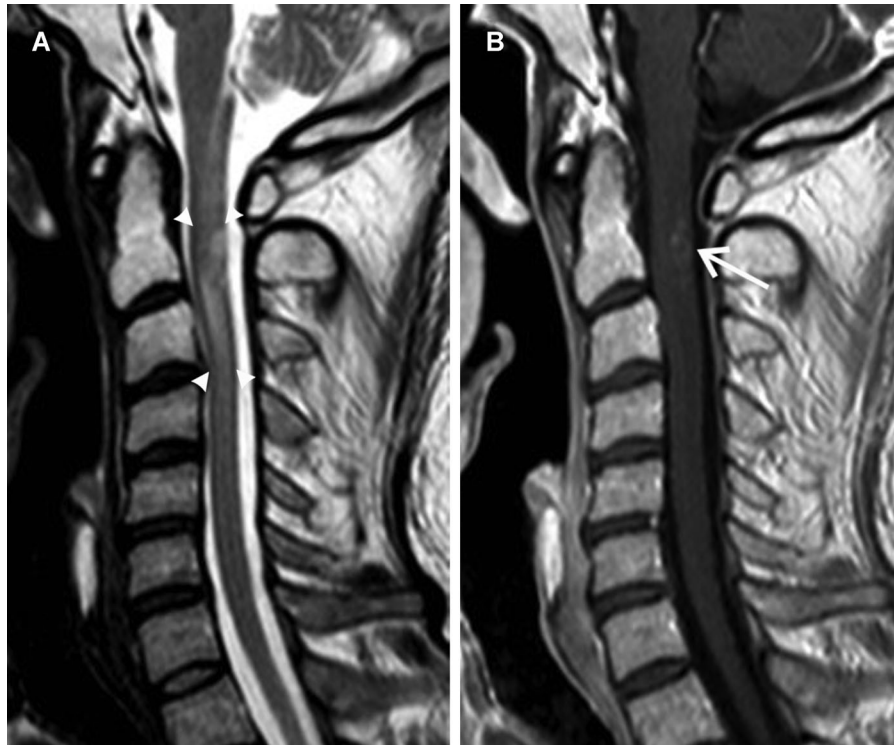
MRI examination performed 7 months after radiotherapy of the C1 infiltration depicts myelopathy with high signal intensity in a T2-weighted image (marked with arrowheads; A), with enhancing lesion after contrast agent's application at C2 level (arrow; B). Tractography reconstruction of the continuous spinal cord fibers without substantial distortions (C). The sagittal reconstruction of the isotropic diffusion image of the spinal cord revealed small areas of high signal intensity in the dorsal part of the spinal cord (arrow) corresponding to the site of the contrast enhancement depicted above (D). The diffusion restriction is confirmed by the small hypointense area in the right dorsolateral part of the spinal cord at the axial image of the ADC map (arrow; E).
